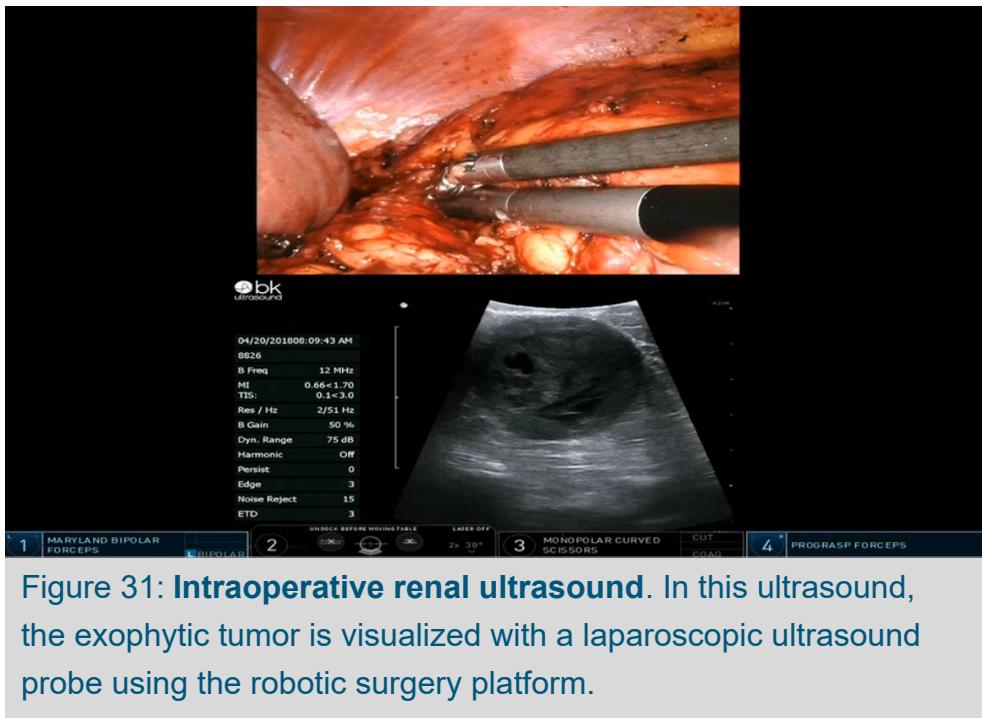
Intraoperative renal ultrasound. In this ultrasound, the exophytic tumor is visualized with a laparoscopic ultrasound probe using the robotic surgery platform.
